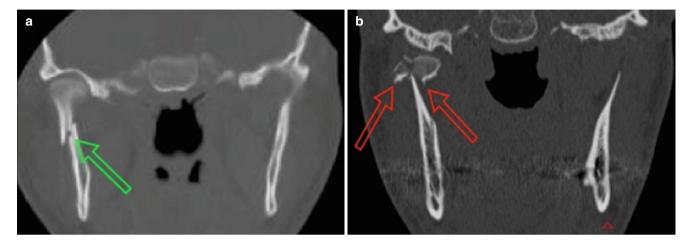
Computed tomography scanning is particularly helpful in assessing complex fractures and those of the mandibular condyle. The *green arrow* in (a) shows a simple oblique fracture of the condylar neck, with some telescoping of the fracture. This is a good candidate for surgical repair. Compare this to the *red arrows* in (b) showing comminution of the head of the condyle. Access and manipulation of all these fragments would be considerably harder
